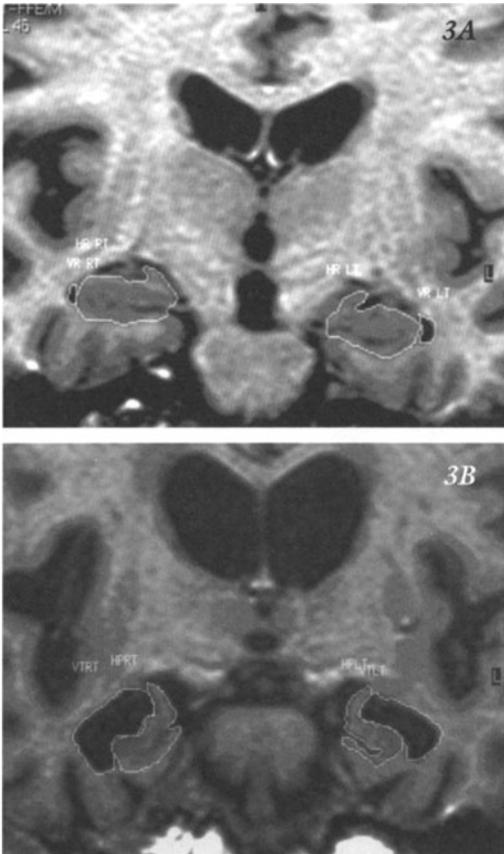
Atrophy of the hippocampus in Alzheimer's disease. MRI: area of hippocampus circled for quantitative analysis. A) Normal hippocampus in a 92-year-old patient with Parkinson's disease but normal cognitive function. B) Severe atrophy of hippocampus in a 72-year-old patient with well developed Alzheimer's disease. Neocortical atrophy is also present. (Courtesy of Dr. Daniel Sax).
